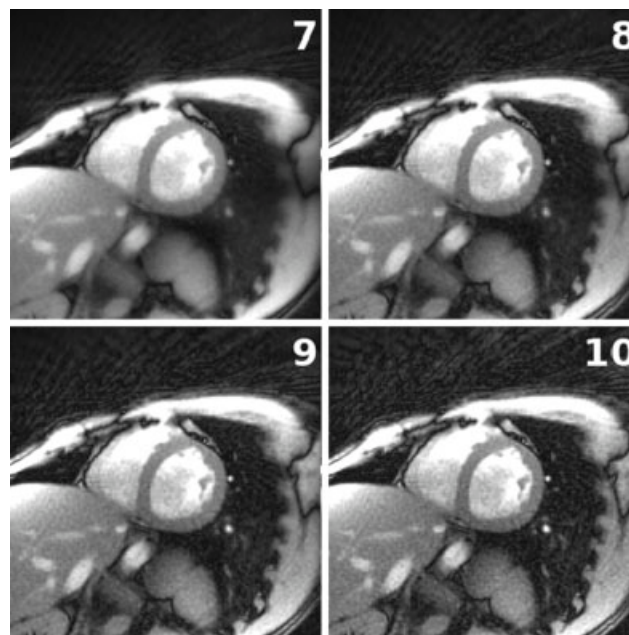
A single frame from a real-time MRI data set of the human heart (short-axis view) acquired with 65 spokes per frame (3 T, radio frequency-spoiled radial FLASH, 128 data points per spoke, 2-fold oversampling to 256 complex samples, pulse repetition time/echo time = 2.0/1.3 ms, 8° flip angle). The nonlinear inverse reconstructions were obtained with a different degree of regularization using seven to 10 Newton steps.
